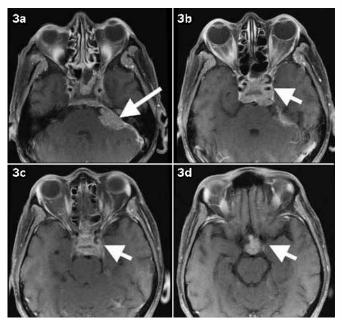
T1-w axial MR image with contrast, one month later, shows (a) rapid progression of the disease. The cerebellopontine angle mass now measures 27 mm \times 23 mm (arrow), and is causing mass effect on the brainstem and cerebellum; (b-d) There is soft tissue infiltration of the sella, suprasellar region and cavernous sinus (arrows).
